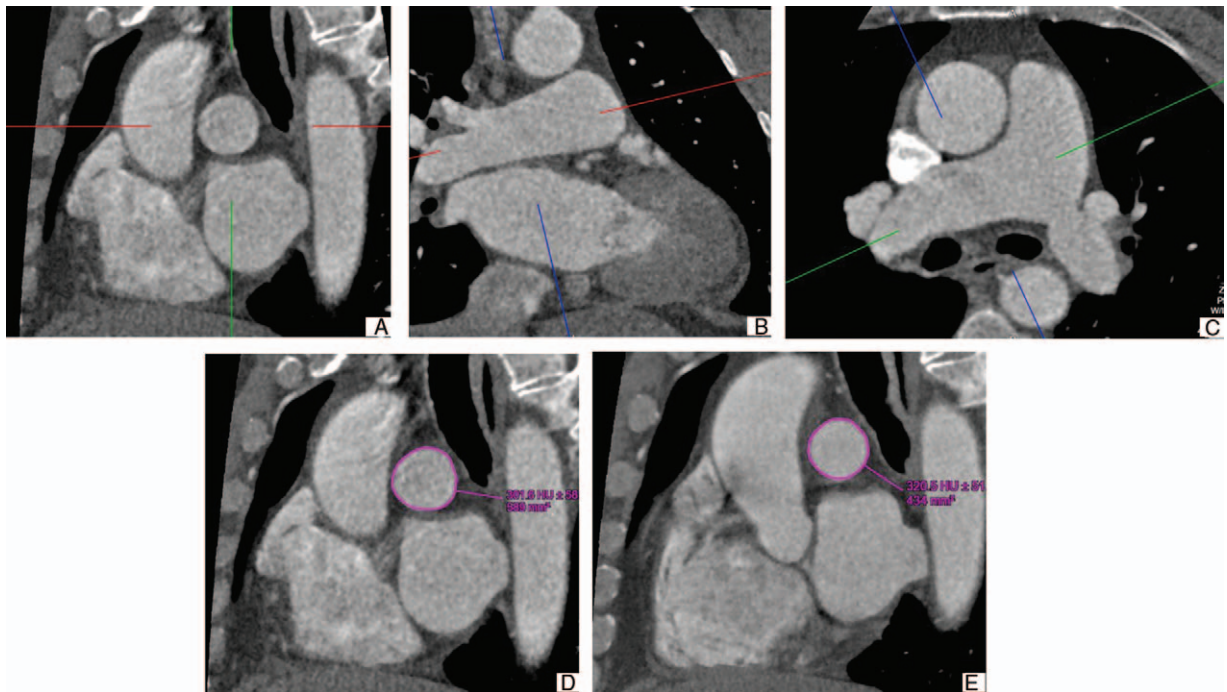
Computed tomography reconstruction plane for right pulmonary artery (RPA) cross-sectional area. (A) Sagittal reconstruction of RPA cross-section after correction for its double obliquity. The plane of reconstruction used for cross-sectional area measurement was adjusted to be perpendicular to the RPA on both (B) coronal and (C) axial views. The manual measurement method of RPA at (D) systolic and (E) diastolic.
